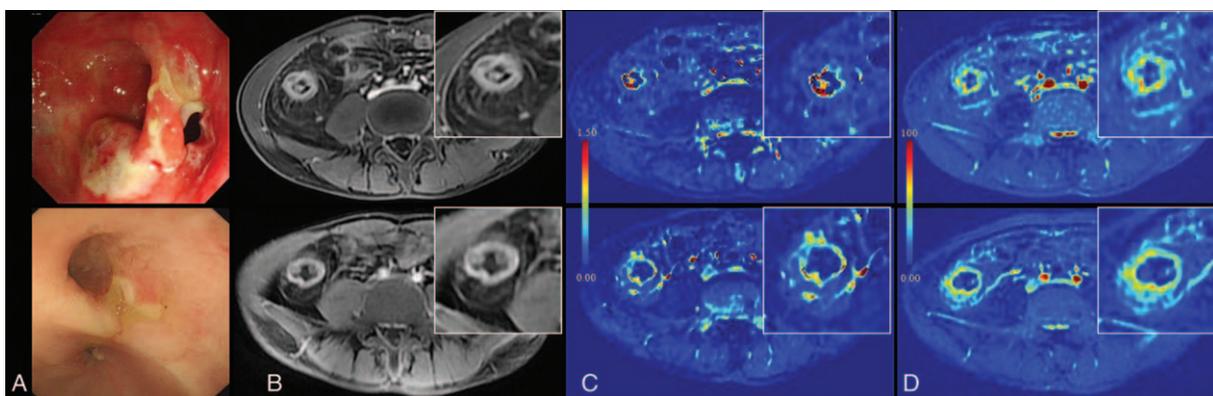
Comparison of endoscopic and MRI images. Endoscopic (A); enhanced T1-weighted (B); K^{trans} (C); BV (D) images of patient 1 acquired pretreatment and post-treatment. Top, pretreatment; bottom, post-treatment. BV=blood volume, K^{trans} =vascular transfer constant, MRI = magnetic resonance imaging.
